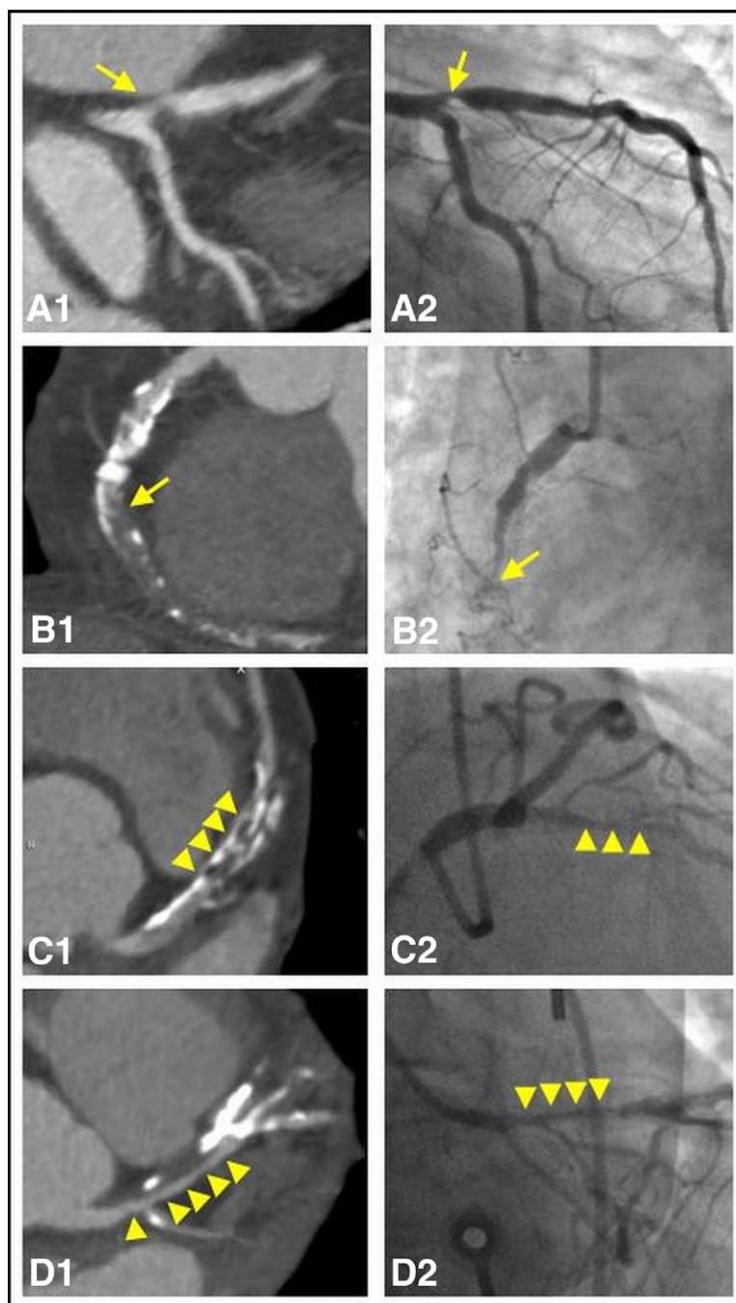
Representative Type C Lesions Identified by CTA and ICA
